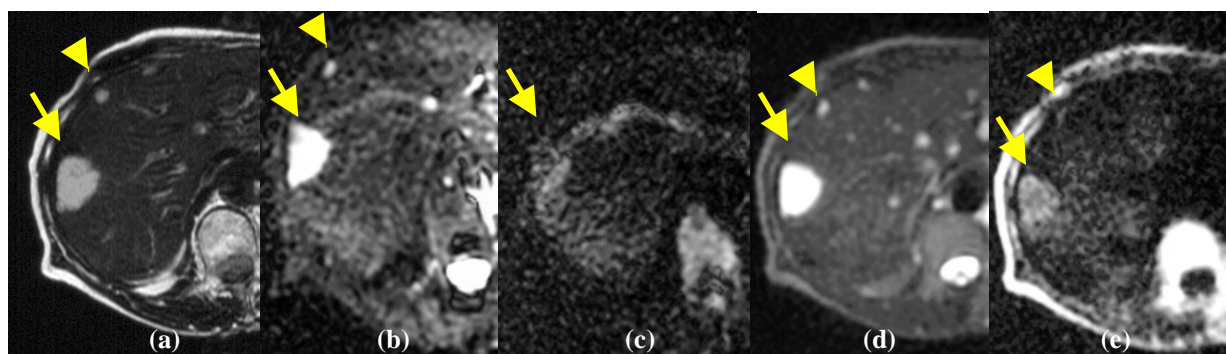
Liver hemangiomas in a 41-year woman. (a) T2-weighted fast spin-echo MR image shows two lesions (arrow and arrowhead) with markedly high signal intensity in the liver. (b) Echo-planar image ($\infty/90$) with a low MPG ($b=4 \text{ sec}/\text{mm}^2$) shows very hyperintense lesions (arrow and arrowhead). (c) Echo-planar image ($\infty/90$) with a high MPG ($b=1000 \text{ sec}/\text{mm}^2$) shows that the signal intensity of the lesion in the right lobe of the liver is markedly decreased (arrow). The lesion in the left lobe of the liver has complete disappeared. (d) SSFSE image ($\infty/92$) with a low MPG ($b=4 \text{ sec}/\text{mm}^2$) shows very hyperintense lesions (arrow and arrowhead). (e) SSFSE image ($\infty/92$) with a high MPG ($b=1000 \text{ sec}/\text{mm}^2$) shows that the signal intensity of the lesion in the right lobe of the liver is moderate decreased (arrow). The lesion in the left lobe of the liver has not disappeared. In peripheral region of livers, the degree of spatial distortion for these lesions was higher EPI than with SSFSE on diffusion-weighted imaging in the same b value.
